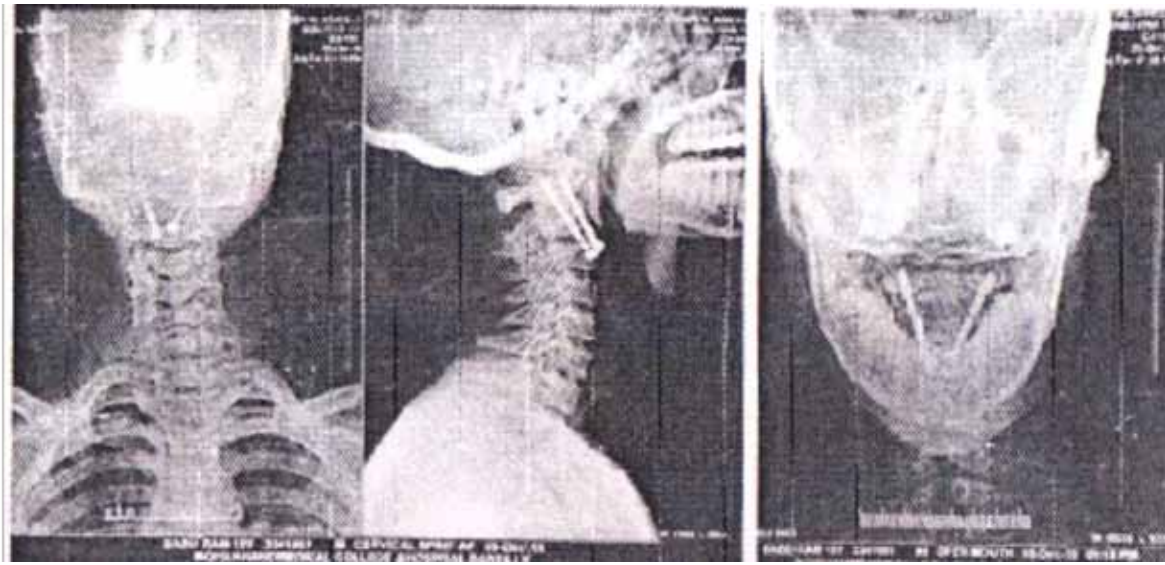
showing postoperative X-rays AP, Lateral and open mouth view after ATS
